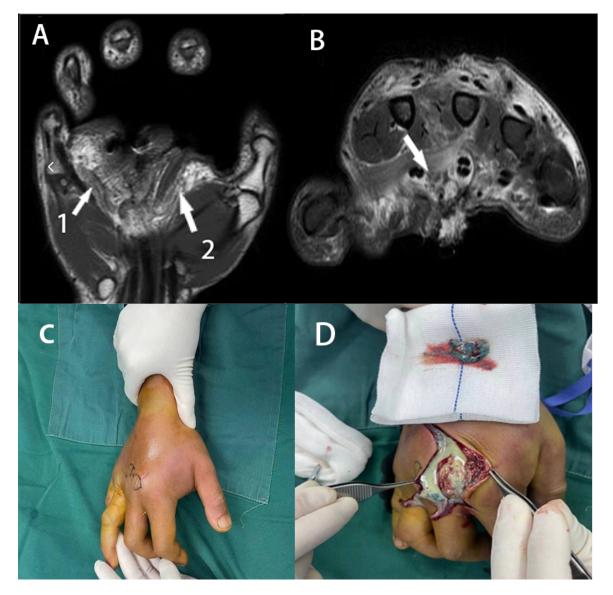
Preoperative MRI images and intraoperative pictures. (A) Arrow 1 presented the extension of the foreign materials within the right hand. Arrow 2 shows edema high signal. (B) Arrow showed slightly low signal, which was considered as a foreign body. (C) External appearance of HPII wound. (D) Polyurethane material in the back of the right hand.
